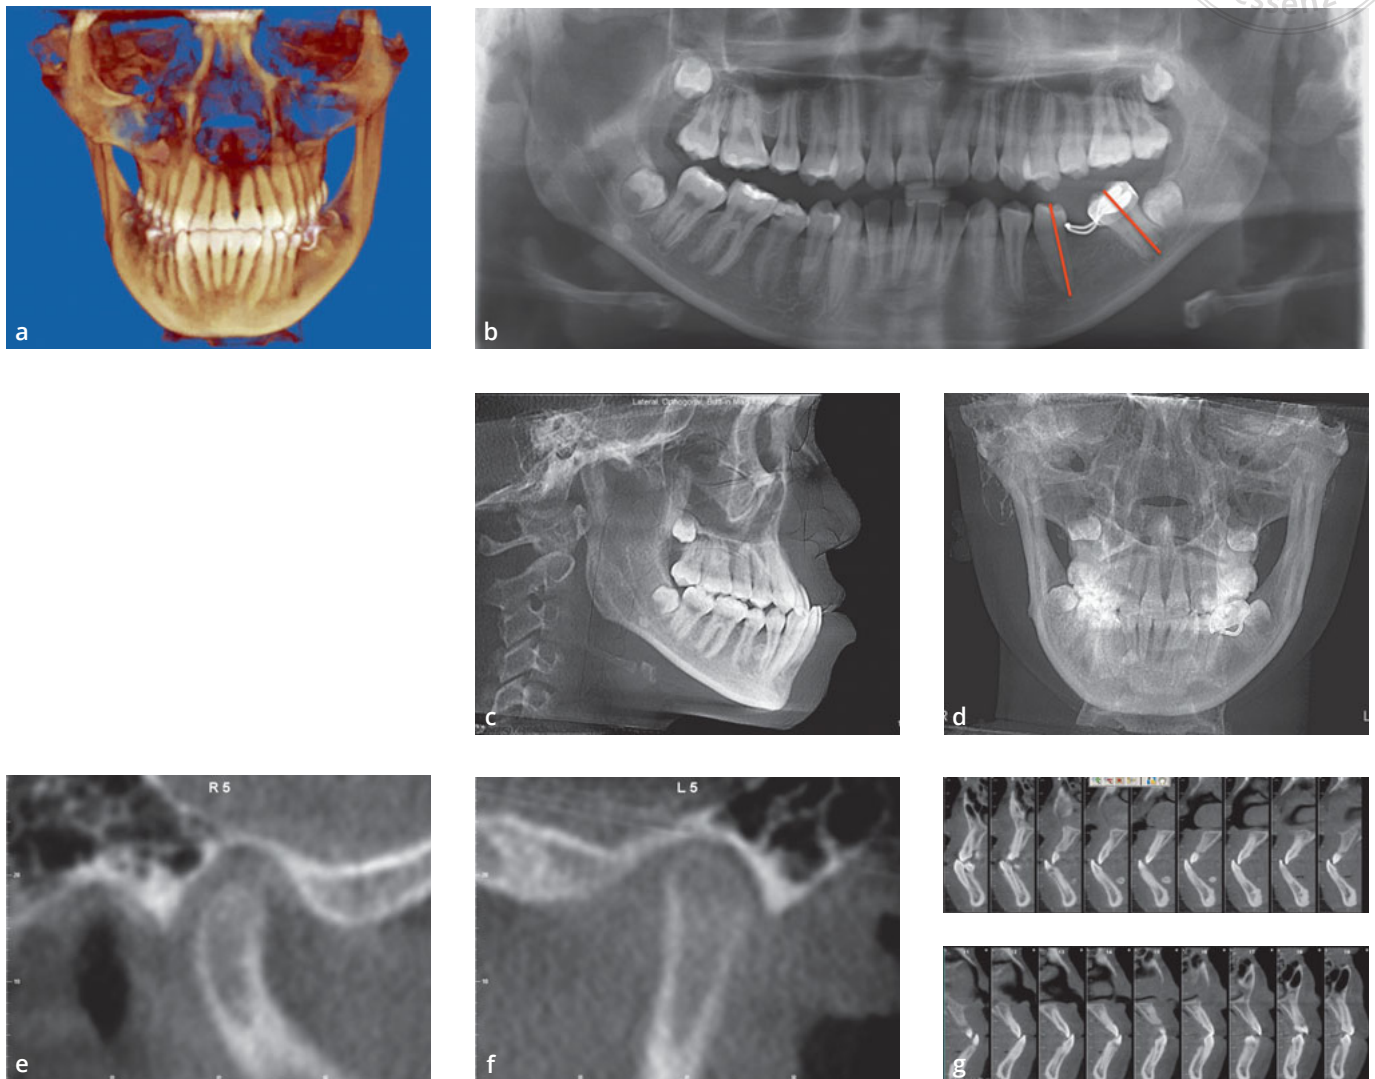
to g Initial cone beam computed tomography (CBCT) imaging. (a) Initial CBCT confirms chin deviation of the patient to the right side. (b) Initial CBCT driven panoramic radiograph showing midline deviation and space of extracted mandibular left first molar. (c) Initial CBCT driven lateral cephalometric radiograph showing concave profile and prominent chin. (d) Initial CBCT driven frontal cephalometric radiograph showing chin deviation to patient's right side. (e and f) Right and left temporomandibular joint (TMJ) imaging before treatment. (g) Initial CBCT driven labiolingual-sagittal screen of the anterior teeth showing the narrow alveolar bone widths and anterior crossbite.
